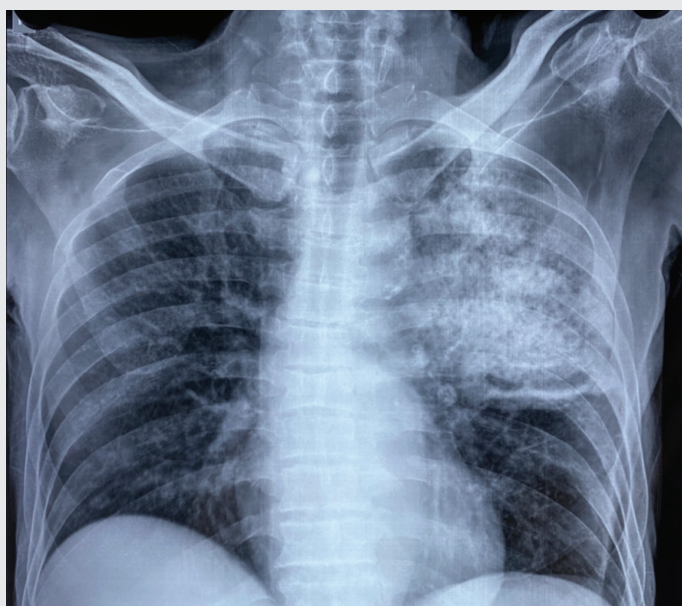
Chest X-ray posteroanterior view showing air space consolidation with central tiny air lucencies
